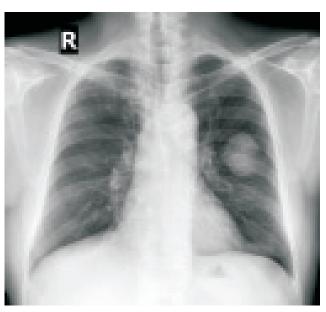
Chest radiograph (postero-anterior view) showing a well-circumscribed mass lesion in the left mid zone.
